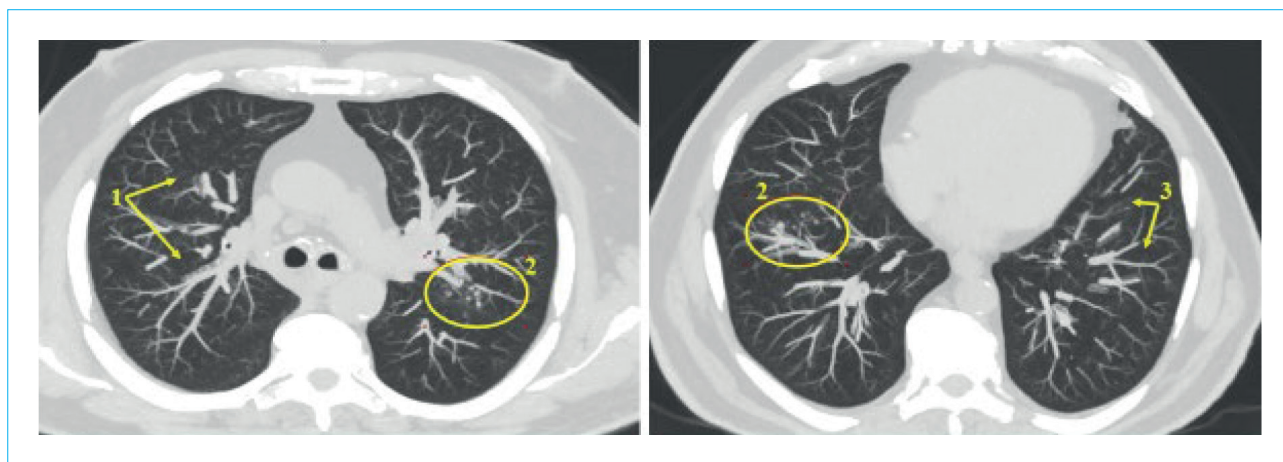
CT scan of the chest organs of Patient B., 54 years old. Multiple centrilobular foci of the “ground glass” type are identified (a slight increase in the density of lung tissue as a result of interstitial inflammation while maintaining the visibility of the walls of blood vessels and bronchi in the area of changes) with unclear contours (1), Y-structures with small nodules at the ends (2), uneven “mosaic” pneumatization of the lungs (a combination of areas of increased and decreased density of lung tissue with obstruction of the small airways) (3)
